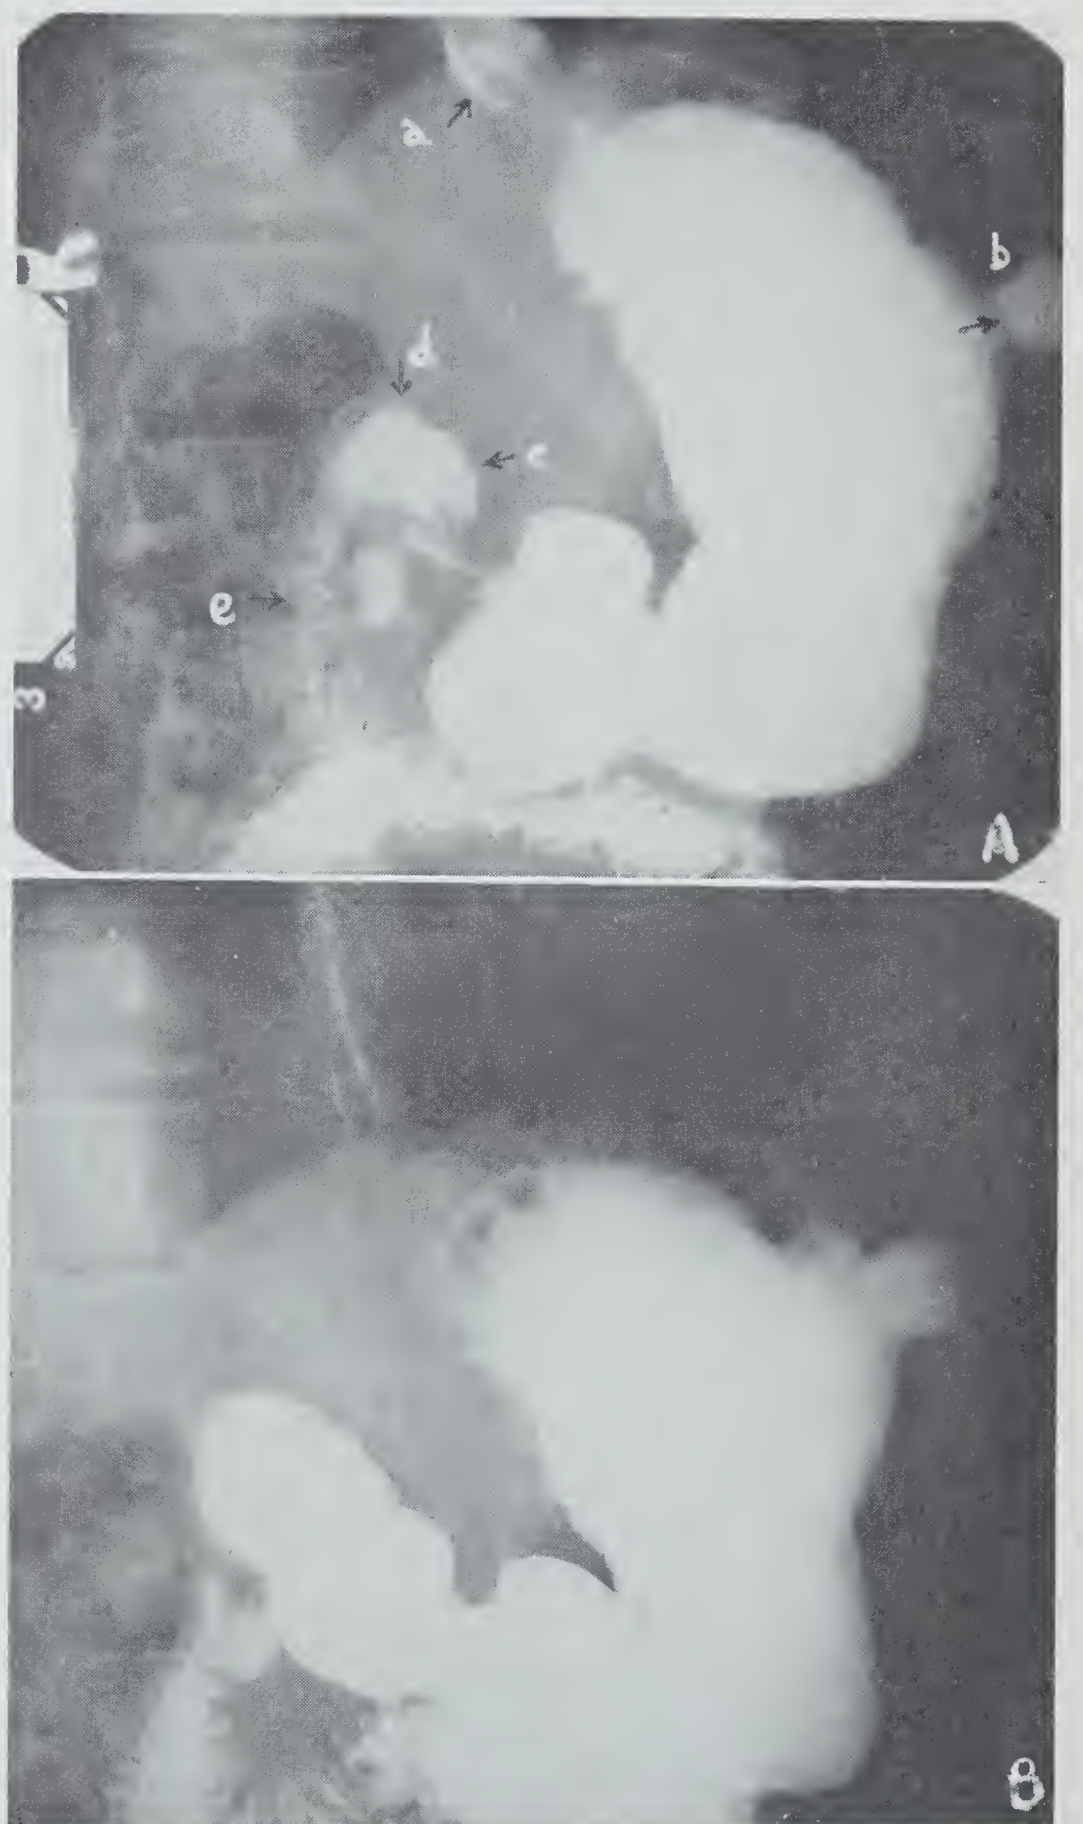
Gastro-intestinal study, dual radiographs: A and B. The salient features are: a. hiatus hernia, b. gastric fundus diverticulum & cutaneous fistula, c. deformity of proximal bulbar recess, d. bulbar diverticulum, e. diverticulum 2nd duodenum.
